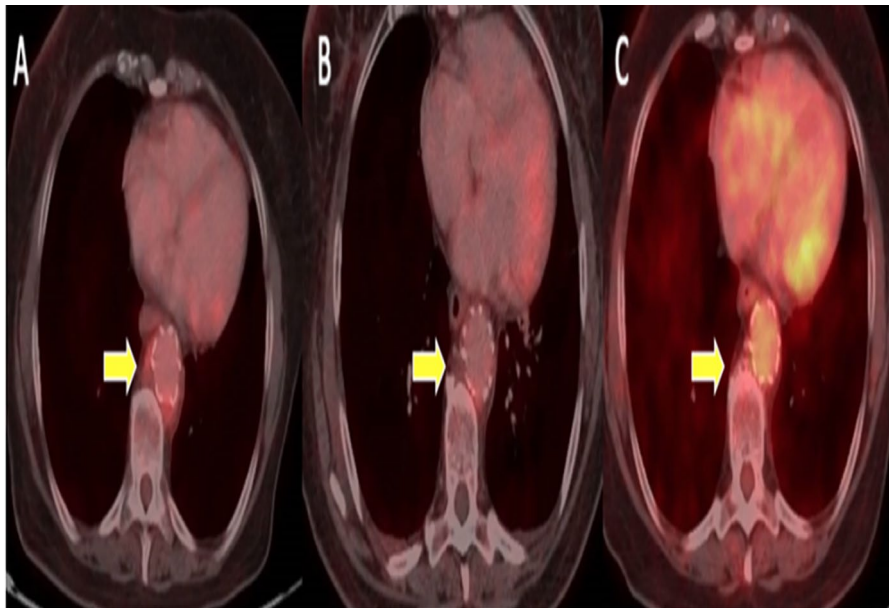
(A) PET-CT scan 3 weeks after the endovascular repair. High activity areas with the presence of infection (arrowed). (B) PET-CT scan 3 months after the endovascular repair. Improvement with a mild activity area of infection (arrowed). (C) PET-CT scan 6 months after the endovascular repair indicates resolution of infection (arrowed). PET-CT indicates positron emission tomography–computed tomography.
